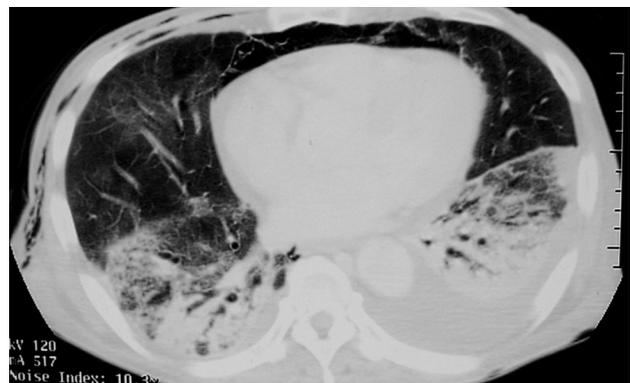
Chest computed tomography (CT) scan image taken before surgical treatment showing compatibility with ARDS.
